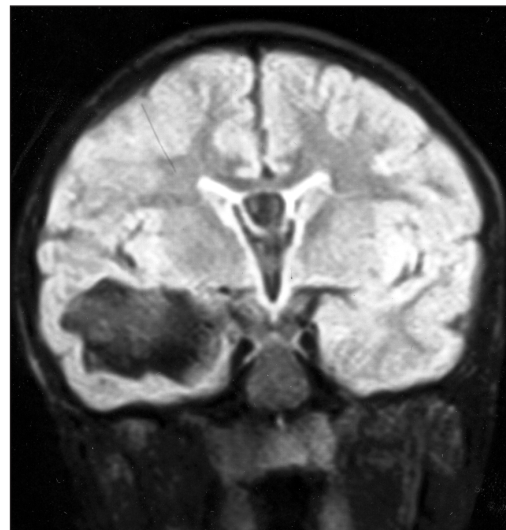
T1-weighted magnetic resonance image performed after 8 months demonstrated an arachnoid cyst in the right middle fossa.
